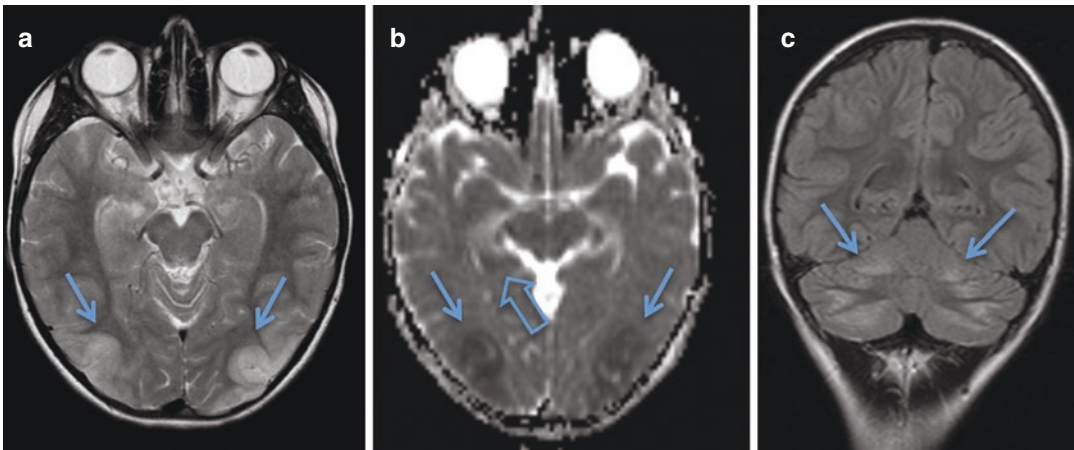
15-year-old girl with flue gas poisoning from an apartment fire. MRI shows cytotoxic edema of the cerebellum (c: arrows), temporo-occipital cortex (a, b: arrows), and hippocampus on both sides. Basal ganglia
